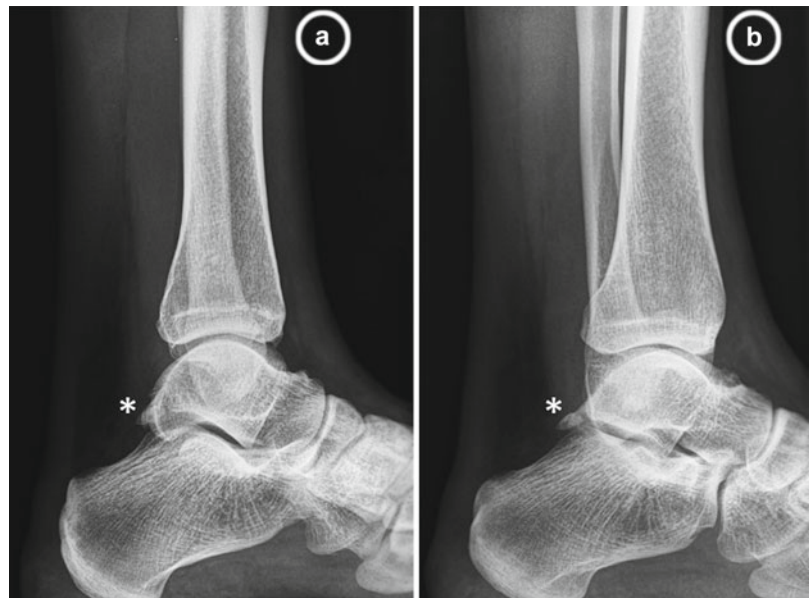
(a) Standard lateral weight-bearing radiograph of the ankle can be negative in relation to a prominent posterior talar process/os trigonum (*). (b) By tilting the beam into a 90° craniocaudal direction with the leg in neutral position and the foot in neutral flexion, bony anomalies in the posterior ankle can more precisely be exposed (* os trigonum)
